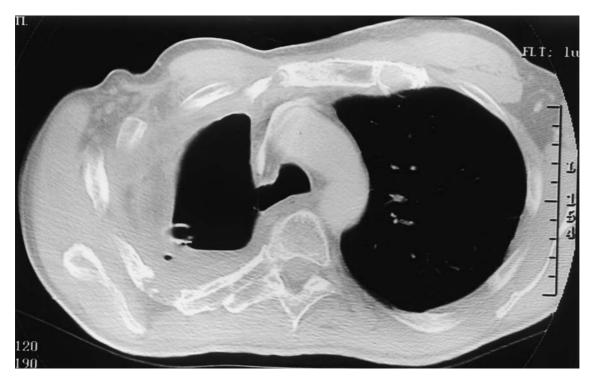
Computed tomography (CT) scan of the chest of a patient, 6 months after right pneumonectomy complicated by a bronchopleural fistula. The empyema space is drained by a large bore catheter. Notice the markedly thickened pleura. The bronchial stump is widely dehisced.
